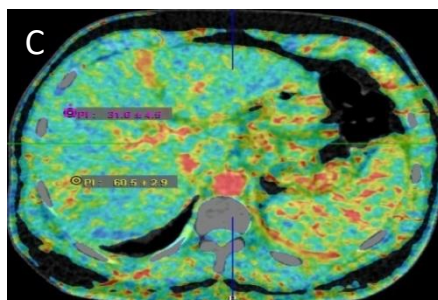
showing the CT perfusion parameters in comparison to the hepatic tissue with high AF (A), low PF (B) and high perfusion index PI (C).
